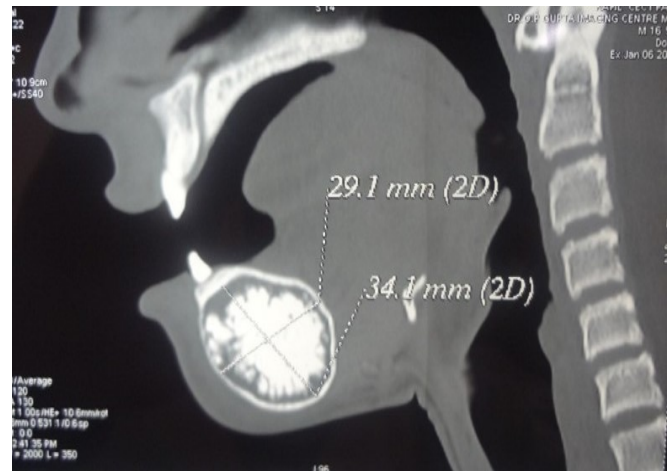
CT scan showed a well-defined unilocular mixed radiolucency measuring 34.1 x 29.1 x 33.5 mm³ & lateral displacement of the neighbouring dental roots without apical resorption.
